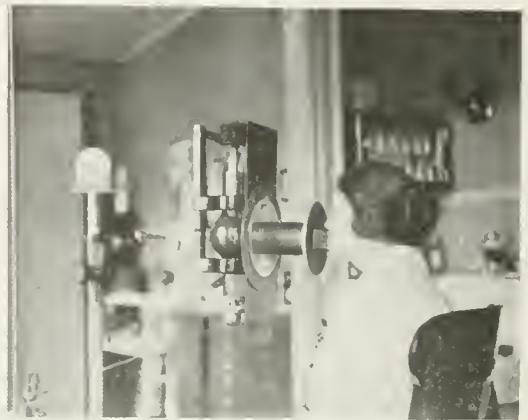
Improved diaphragm allowing the x-ray to be applied to a definite area. Recording the area by marking automatically a square area which received the ray.
